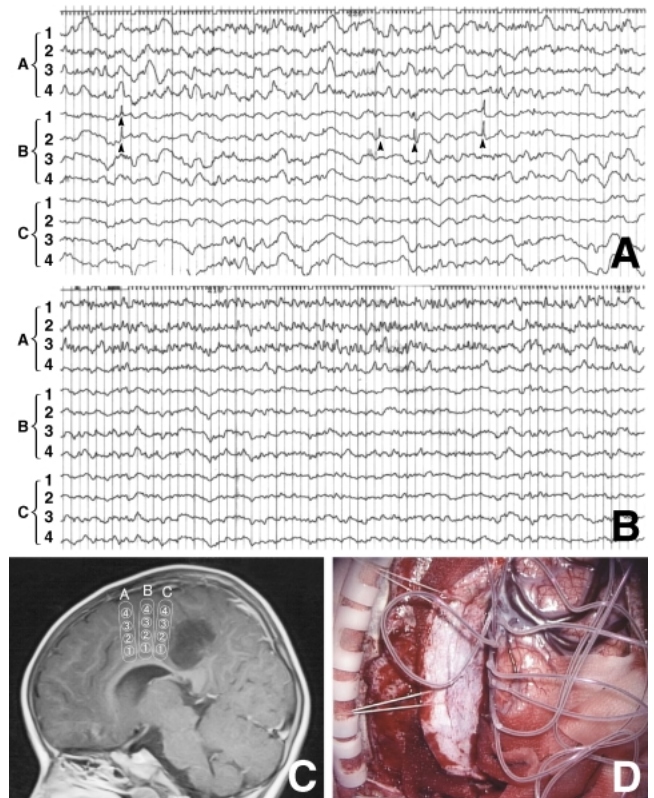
A, B: Intraoperative electrocorticograms demonstrating frequent spikes (arrowheads) from the right cingulate gyrus subjacent to the anterior side of the tumor (A), which immediately disappeared after resection of the tumor (B). C: T₁-weighted magnetic resonance image showing the spikes originated in regions B-1 and B-2. D: Intraoperative photograph of the electrocorticography procedure during the operation.
